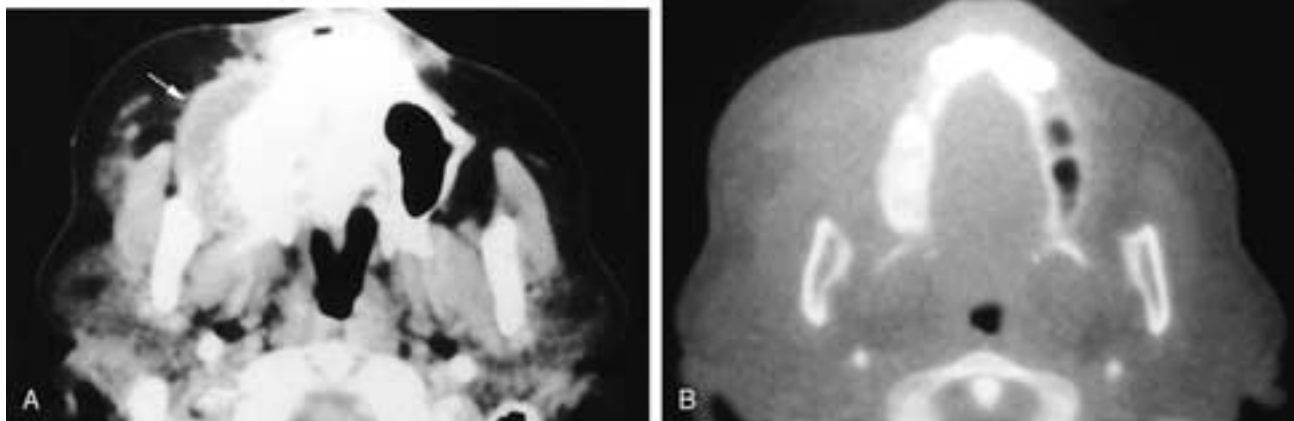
Axial CT scans viewed at “soft-tissue” (A) and “bone” (B) window settings show a nonossified mass along the outer margin of the right maxillary alveolus (*arrow*). The alveolus in this area is minimally enlarged and very dense. This patient had an osteogenic sarcoma.
